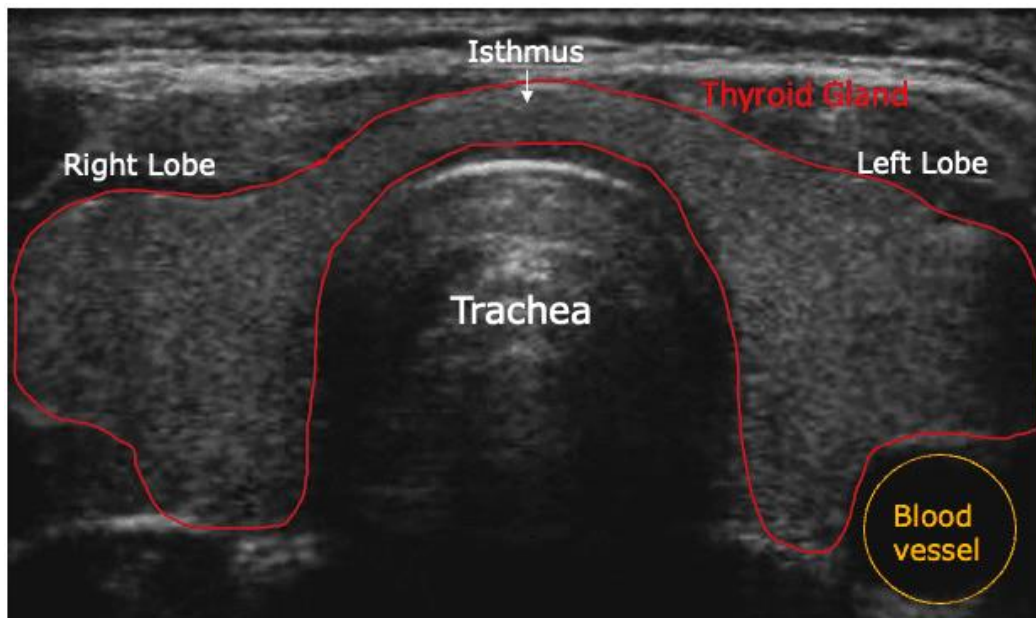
Ultrasonography of a healthy normal thyroid gland (STARmed America, 2025)
